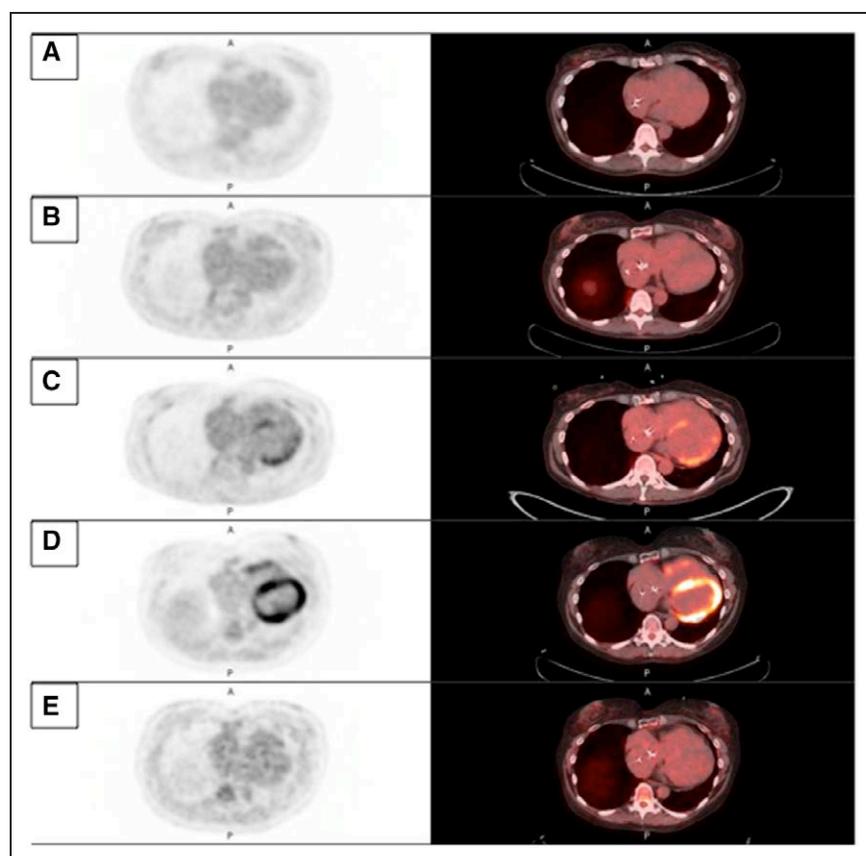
F-18 fluorodeoxyglucose (^{18}F -FDG) cardiac positron emission tomography/computed tomography (PET/CT) images.
